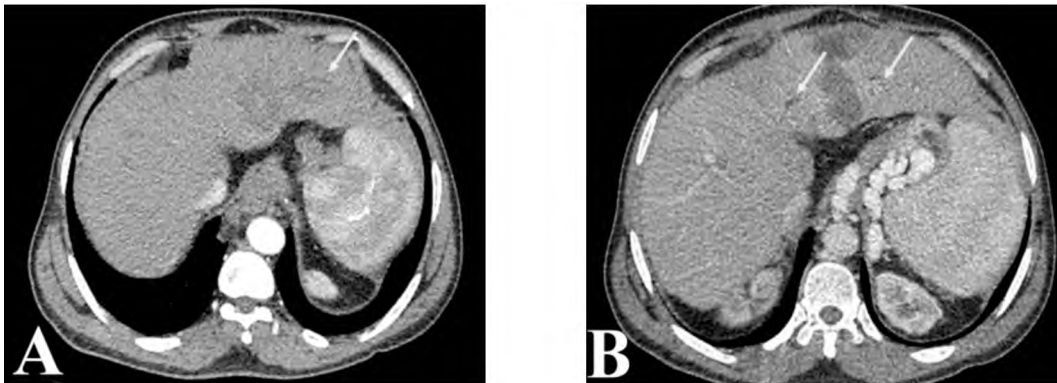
Male patient aged 56 years old with hepatitis C cirrhosis. A triphasic CT abdomen was done and revealed 2 HCCs at the lateral segment of the left liver lobe. Microwave ablation of the 2 adjacent left liver lobe HCC was done. The patient was evaluated by triphasic CT of the abdomen two weeks after the procedure revealing complete ablation of left liver lobe HCC with peri-focal biliary dilatation. (A,B): Triphasic CT abdomen (A): Arterial (B): Portal phases showing a well-defined area of MWA in the left lobe segment II/III interface with no enhancement in all phases impressive of completely ablated HCC with peri-focal biliary dilatation (Yellow arrow).
